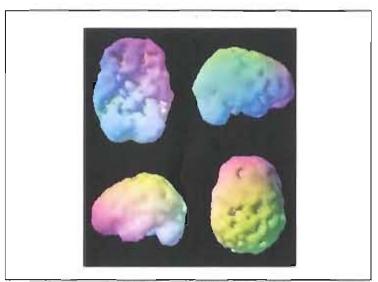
SPECT brain scan images of daily Alcohol Use. Copyright by Amen Clinics Inc. Printed with permission from MindWorks Press and Amen Clinics Inc.
